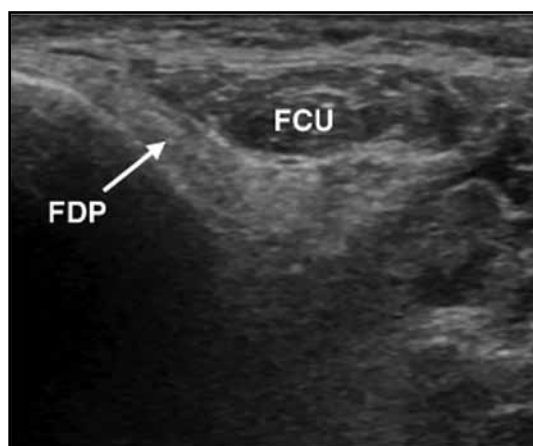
Ultrasound of the forearm in a patient with inclusion body myositis demonstrating greater abnormalities in flexor digitorum profundus (FDP) relative to flexor carpi ulnaris (FCU).
